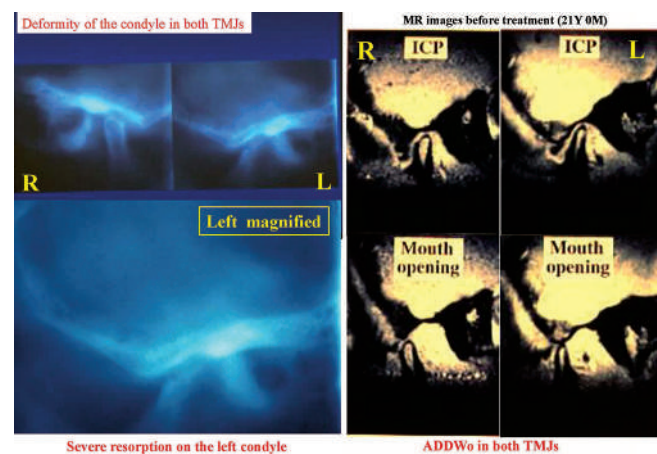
Severe resorption of left condyle on lateral tomograms (left) and anterior displacement of articular disk without reduction on magnetic resonance images (right)
